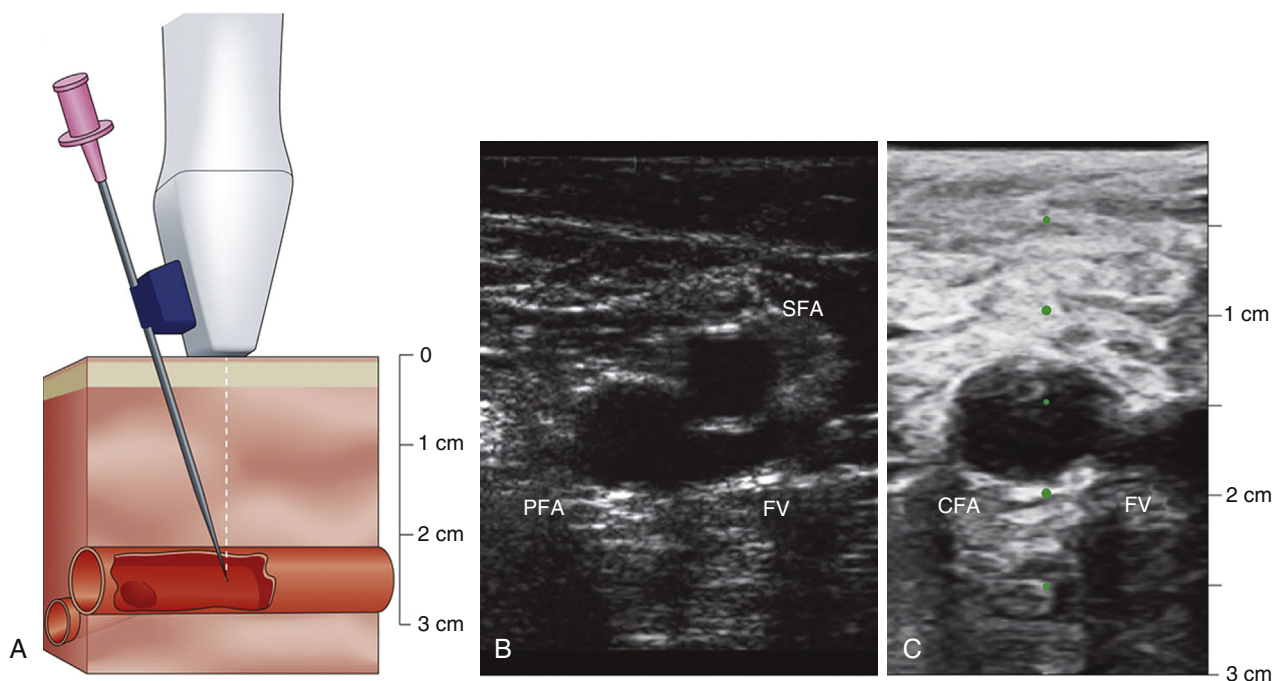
Ultrasound-guided femoral artery access. A, The attached needle guide fixes the needle’s angle of entry to intersect the vessel at the imaging plane 1.5 cm, 2.5 cm, or 3.5 cm below the skin, depending upon the guide chosen. The vessel bifurcation is kept inferior to the probe at the time of insertion. B, The right femoral artery bifurcation is imaged in the axial plane, identifying the separation of the profunda femoral artery (PFA) and superficial femoral artery (SFA). Compression is used to differentiate arteries from the femoral vein (FV). C, The probe is moved superiorly until the common femoral artery (CFA) is visualized. During needle advancement, the anterior wall of the vessel is kept under the central target line (*green dots*), which indicates the path of the needle. (From Seto A, et al. Real-time ultrasound guidance facilitates femoral arterial access and reduces vascular complications: FAUST (Femoral Artery Access with Ultrasound Trial). *JACC Cardiovasc Interv* 2010;3:751.)
